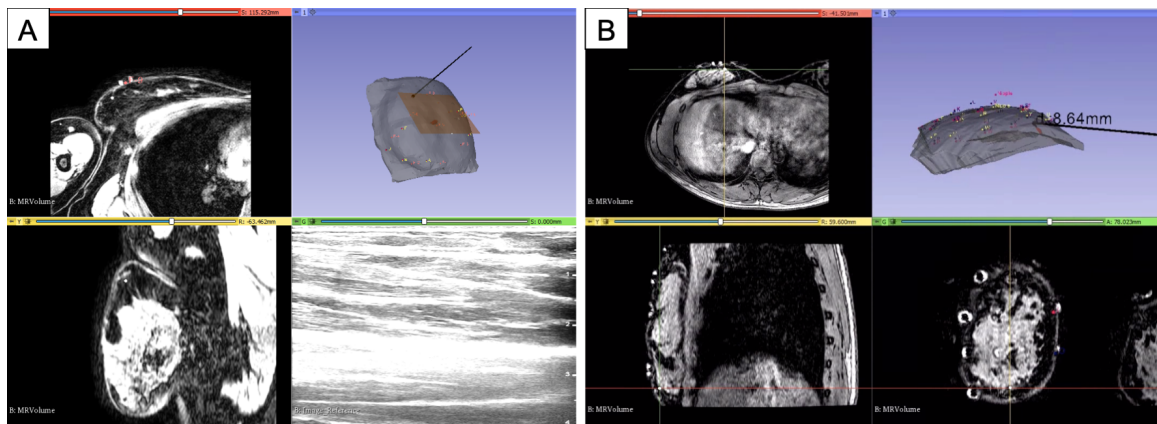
Image guidance system four-panel displays. (A) Display using tracked US probe: MR axial and sagittal slice views (left), live ultrasound feed (right bottom) and 3D rendering, with tumor segmentation in red, surface points, stylus in black, and model of the tracked ultrasound plane in transparent orange (right top). (B) Display using tracked stylus: MR axial, sagittal and coronal slice views each with cross-hair positioning of the tracked stylus (left top, left bottom, right bottom, respectively), and model of the breast, tumor, and tracked stylus with surface points and the distance from stylus to tumor (top right).
